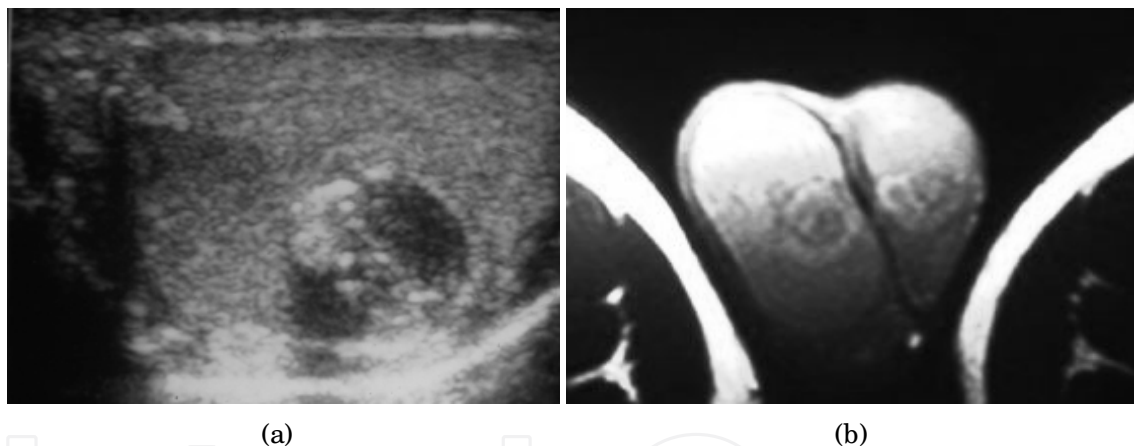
Testicular epidermoid cysts. (a) Typical sonographic pattern showing cystic lesion with an echogenic ring and some internal echogenic spots. (b) Magnetic resonance imaging was compatible with the diagnosis. This patient then underwent conservative surgery
